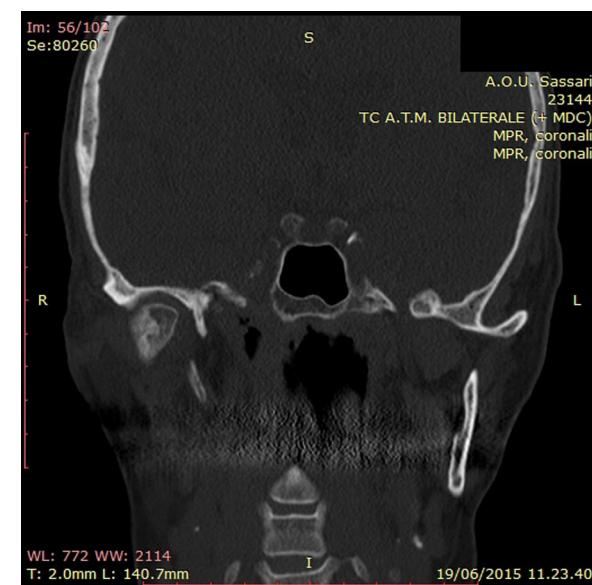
Right TMJ CT-scan showing osteosclerotic areas alternate to 3–5 mm in diameter osteolytic lesions.
